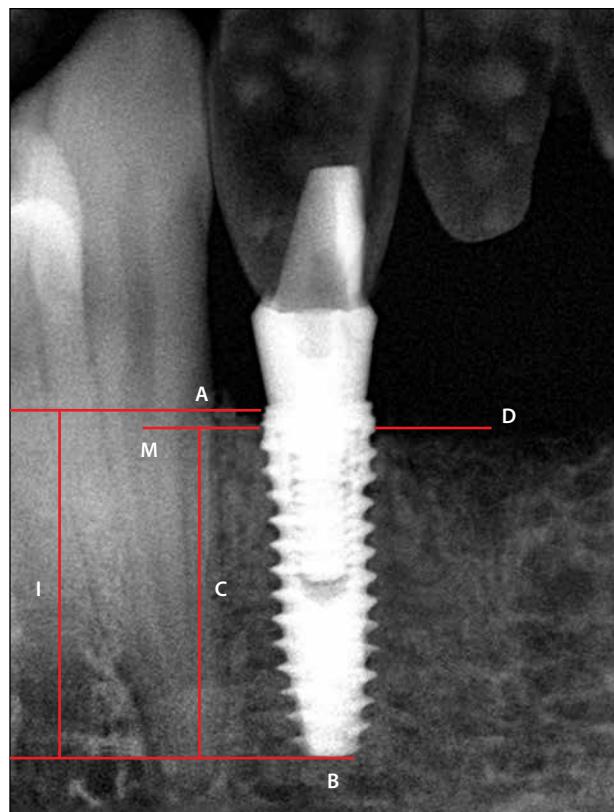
Different measurements in periapical radiograph at last follow-up visit (7 years follow-up) in patient with definitive FPD constructed from PEEK with type A loading protocol. Measurements are labeled as the following: (A) coronal end of implant body, (B) apical end of implant body, (M) mesial bone crest, (D) distal bone crest, (I) length of the implant body, and (C) space between the top of the bone crest and the apical end of the implant.
